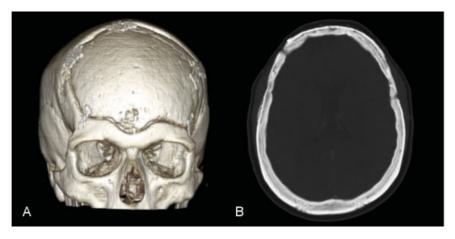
(A) Three-dimensional and (B) axial computed tomography scans 19 months after surgery, demonstrating feathering of bone edges with preservation of normal contours.
